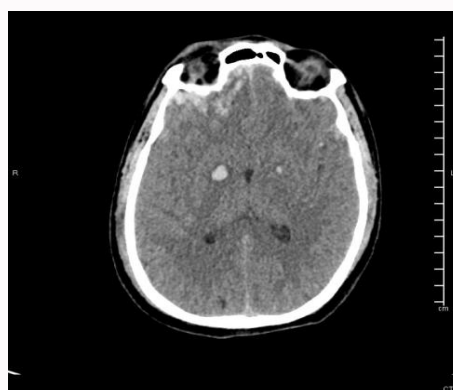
Axial CT scan at low ventricular level showed multiple hemorrhagic contusions in both frontal lobes, and bilateral gangliocapsular region hemorrhages larger on the right side with a diameter of 12 mm, and left 7 mm.
